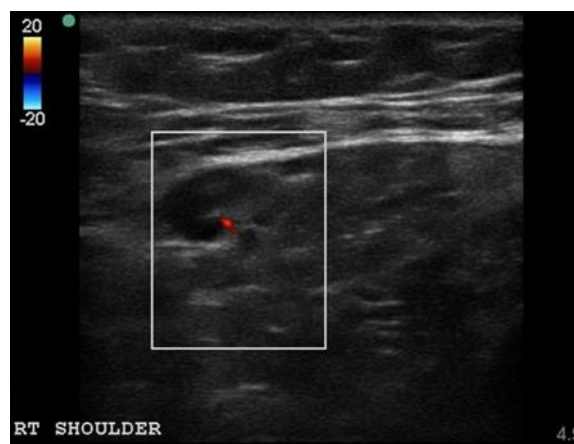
Case 1. Color Doppler ultrasound assessment of the right axillary region revealing positive color Doppler findings of the swollen lymph node.
